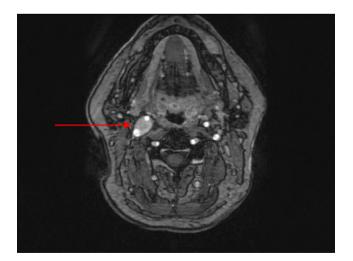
Axial magnetic resonance imaging (MRI) of the head and neck region showing a Shamblin type II carotid body paraganglioma. 3D TOF (time-of-flight angiography) sequence is used to visualise flow within vessels, without the need to administer contrast intravenously
